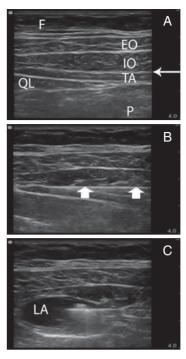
Sonographic anatomy of the US-guided TAP block. Images show the lateral abdominal wall using a probe held in the mid-axillary line in the axial plane. The right of the image is anterior. (A) Narrow arrow, TAP; EO, external oblique muscle; IO, internal oblique muscle; TA, transversus abdominis muscle; QL, quadratus lumborum muscle; F, s.c. fat; P, intraperitoneal structures. (B) Broad arrows, needle with the tip positioned in the TAP. (c) Local anaesthetic forming a lens-shaped space in the TAP; LA, local anaesthetic.
